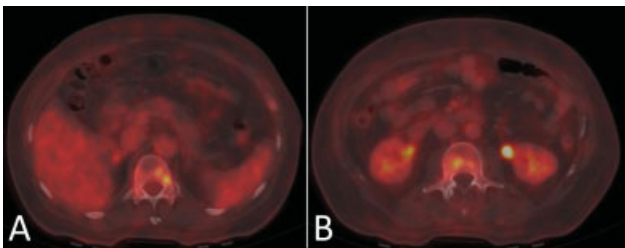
18-F FDG PET-CT fusion images (A and B) showing heterogeneously increased tracer uptake in the posterior parts of vertebral bodies. CT, computed tomography; FDG PET, fluorodeoxyglucose positron emission tomography.
